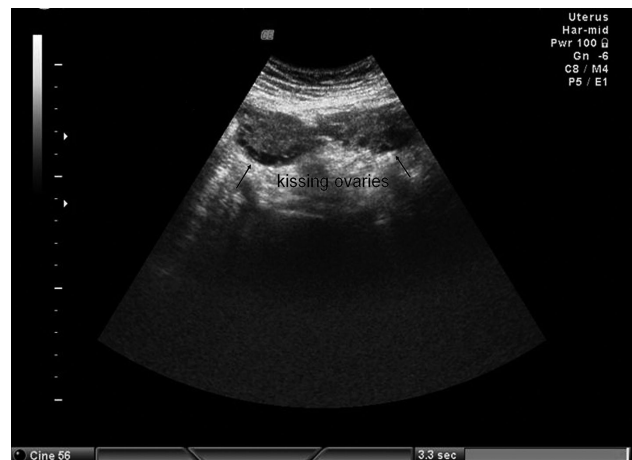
Ultrasound examination demonstrating the two ovaries appear to be attached to each other as "kissing ovaries."
